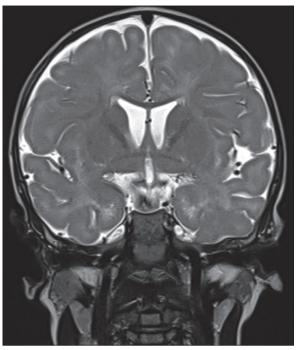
Brain MRI, coronal section, T2 sequence. Hyperintensity of the fundamentally subcortical white matter and U-shaped fibres, compatible with hypomyelination. The corpus callosum is correctly myelinated.
